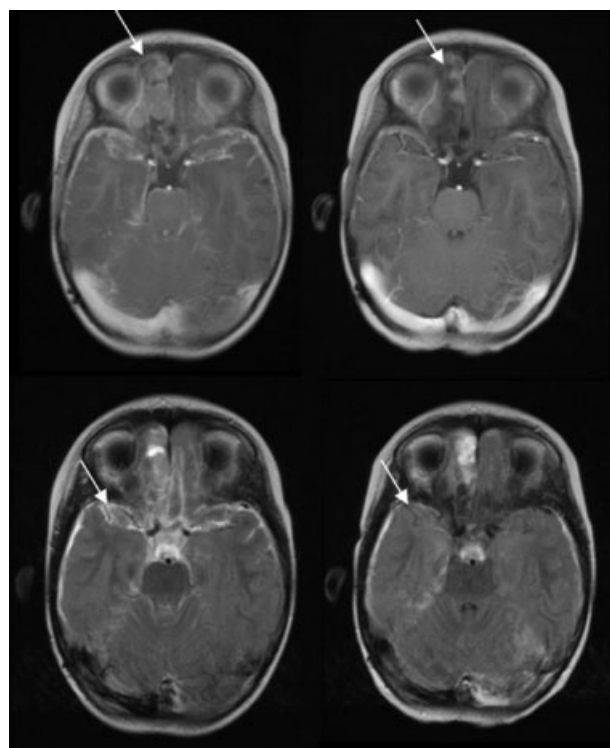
Magnetic resonance imaging (MRI) of a partial response of recurrent pineoblastoma to the oxaliplatin and etoposide regimen. Before the initiation of therapy, (*Top*) postcontrast axial T1 and (*Bottom*) postcontrast fluid attenuation inversion recovery (FLAIR) MRI scans showed a metastasis in the (top left) right cribriform region and (top left and bottom left) diffuse leptomeningeal tumor within sulci and basilar cisterns (arrows). (Bottom left) Some enhancement within the cerebrospinal fluid was also noted on the postcontrast FLAIR image. A decrease in the size of (top right) the solid metastasis and (bottom right) the extent of diffuse leptomeningeal tumor occurred with therapy.
